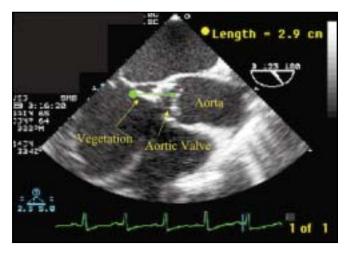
Image 1_Trans-esophageal echocardiographic study of the patient described in this study. Vegetation (Green Line) on the aortic valve was present and floating freely upon trans-esophageal echocardiography in this patient upon presentation.
